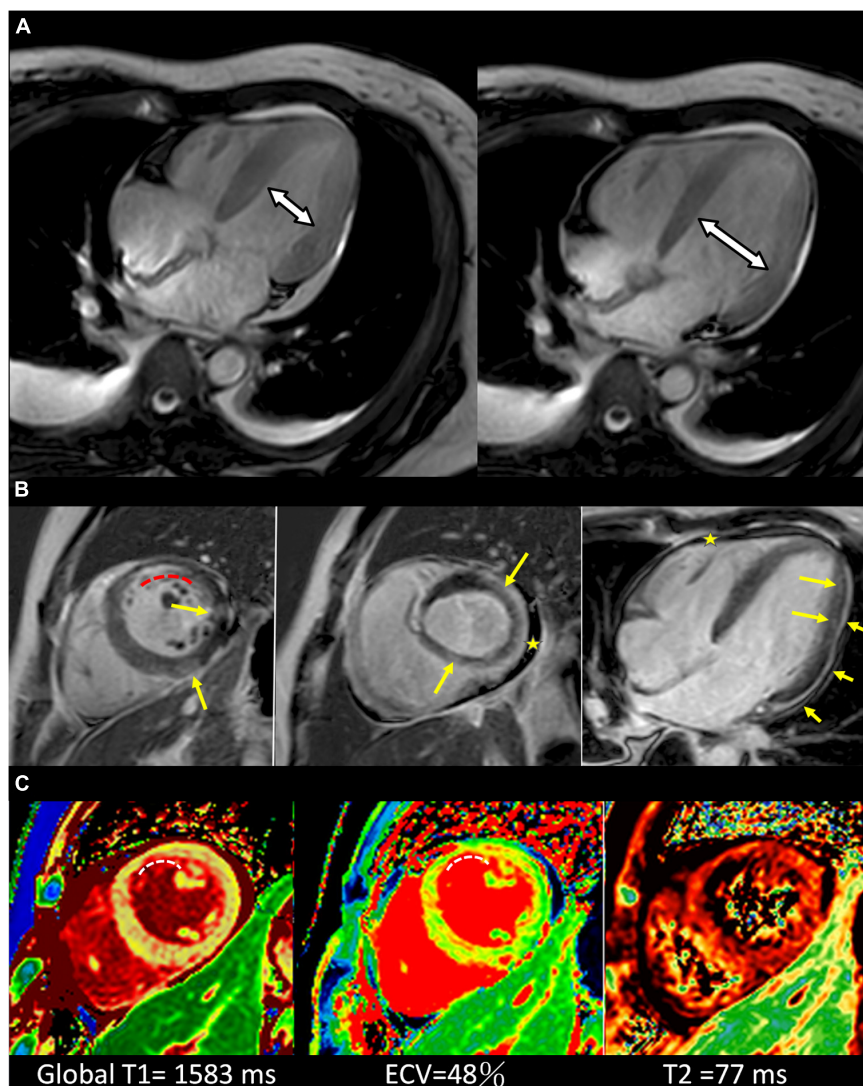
Cardiac MRI of the patient. (A) Cardiac MR 4-chamber cine end-systolic (left) and end-diastolic (right) images show the limited LV dimensional change, indicative of the impaired LV systolic function. (B) Cardiac MR late Gadolinium enhancement images of short-axis (left, middle) and 4-chamber (right) view. Yellow arrows depict the patchy enhancements sparsely distributed in the mid-layer and subepicardium in a non-ischemic pattern, arrowheads depict pericardial enhancement and stars depict pericardial effusion. The curved dashed line depicts the subendocardial enhancement in the antero-septal subendocardium of LV mid-cavity which is within the LAD territory. (C) T1 map (left), ECV map (middle) and T2 map (right) in short-axis views show elevated T1, ECV, and T2 values, indicating acute myocardial injury (global T1 = 1,583 ms, ECV = 48%, T2 = 77 ms; institution-specific cut-off values for abnormal myocardium: T1 global $\geq 1,250$ ms, T2 global ≥ 60 ms). CMR findings meet updated 2018 Lake Louise criteria for acute myocarditis (25). The curved dashed lines depict the focally elevated T1 and ECV values in the antero-septal subendocardium, equivalent to the enhanced area depicted in (B).
